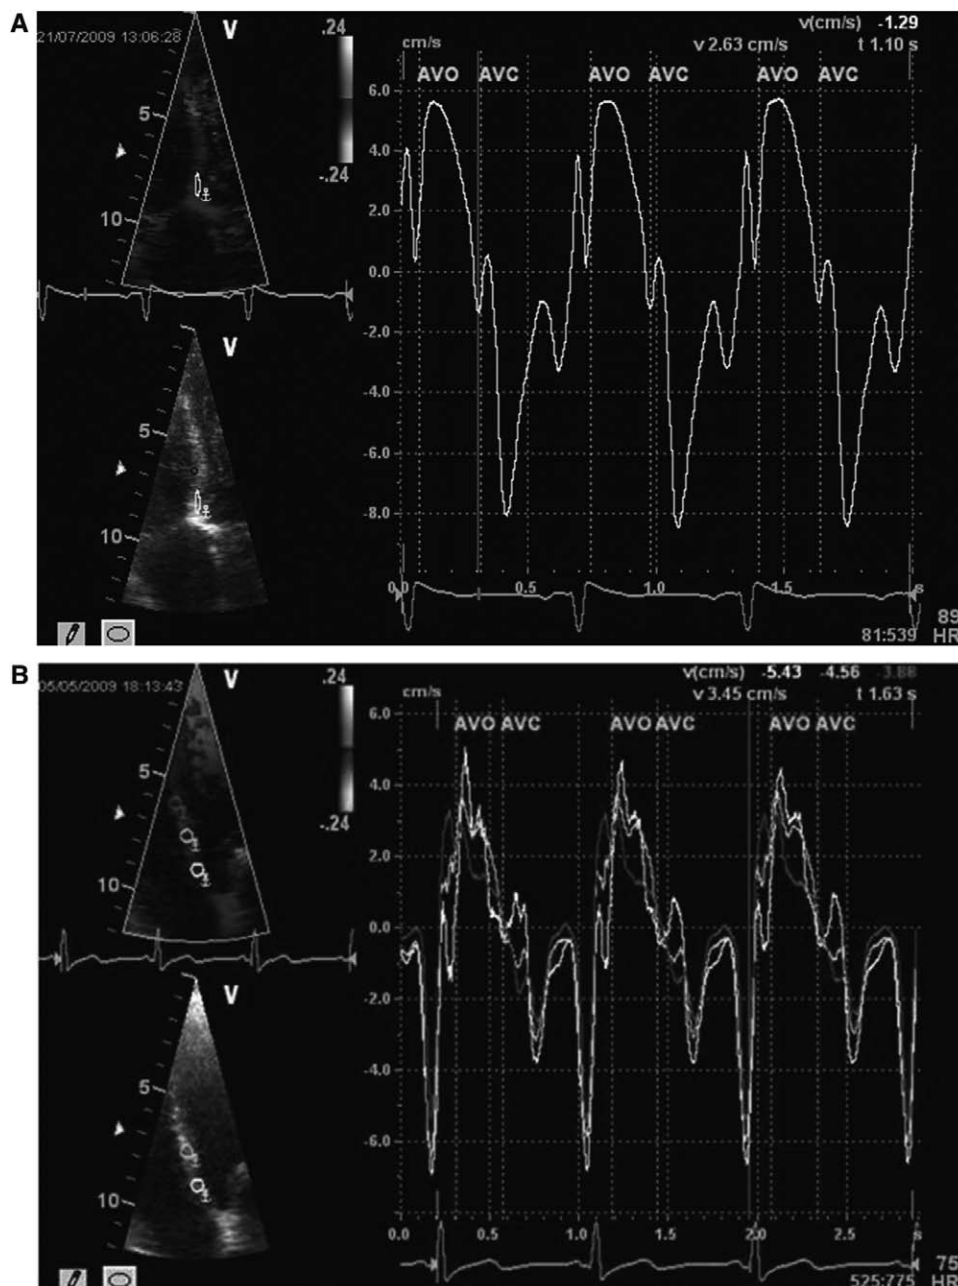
Color tissue Doppler (CTD) velocity curves at the level of the basal septum in a pregnant control (A) and at the level of multiple sites in an Asian patient with preeclampsia aged 35 years at 30 weeks of gestation (B). The case and control are matched for ethnicity, maternal age, and gestational age at assessment. It is possible to appreciate the early (Em) to late (Am) peak diastolic CTD velocity ratio inversions ($Em/Am < 1$) at the level of all investigated sites in the woman with preeclampsia (B) vs a normal Em/Am ratio > 1 in the control (A). This abnormal myocardial velocity pattern is suggestive of diastolic dysfunction in the woman with preeclampsia. AVC indicates aortic valve closing; and AVO, aortic valve opening.
